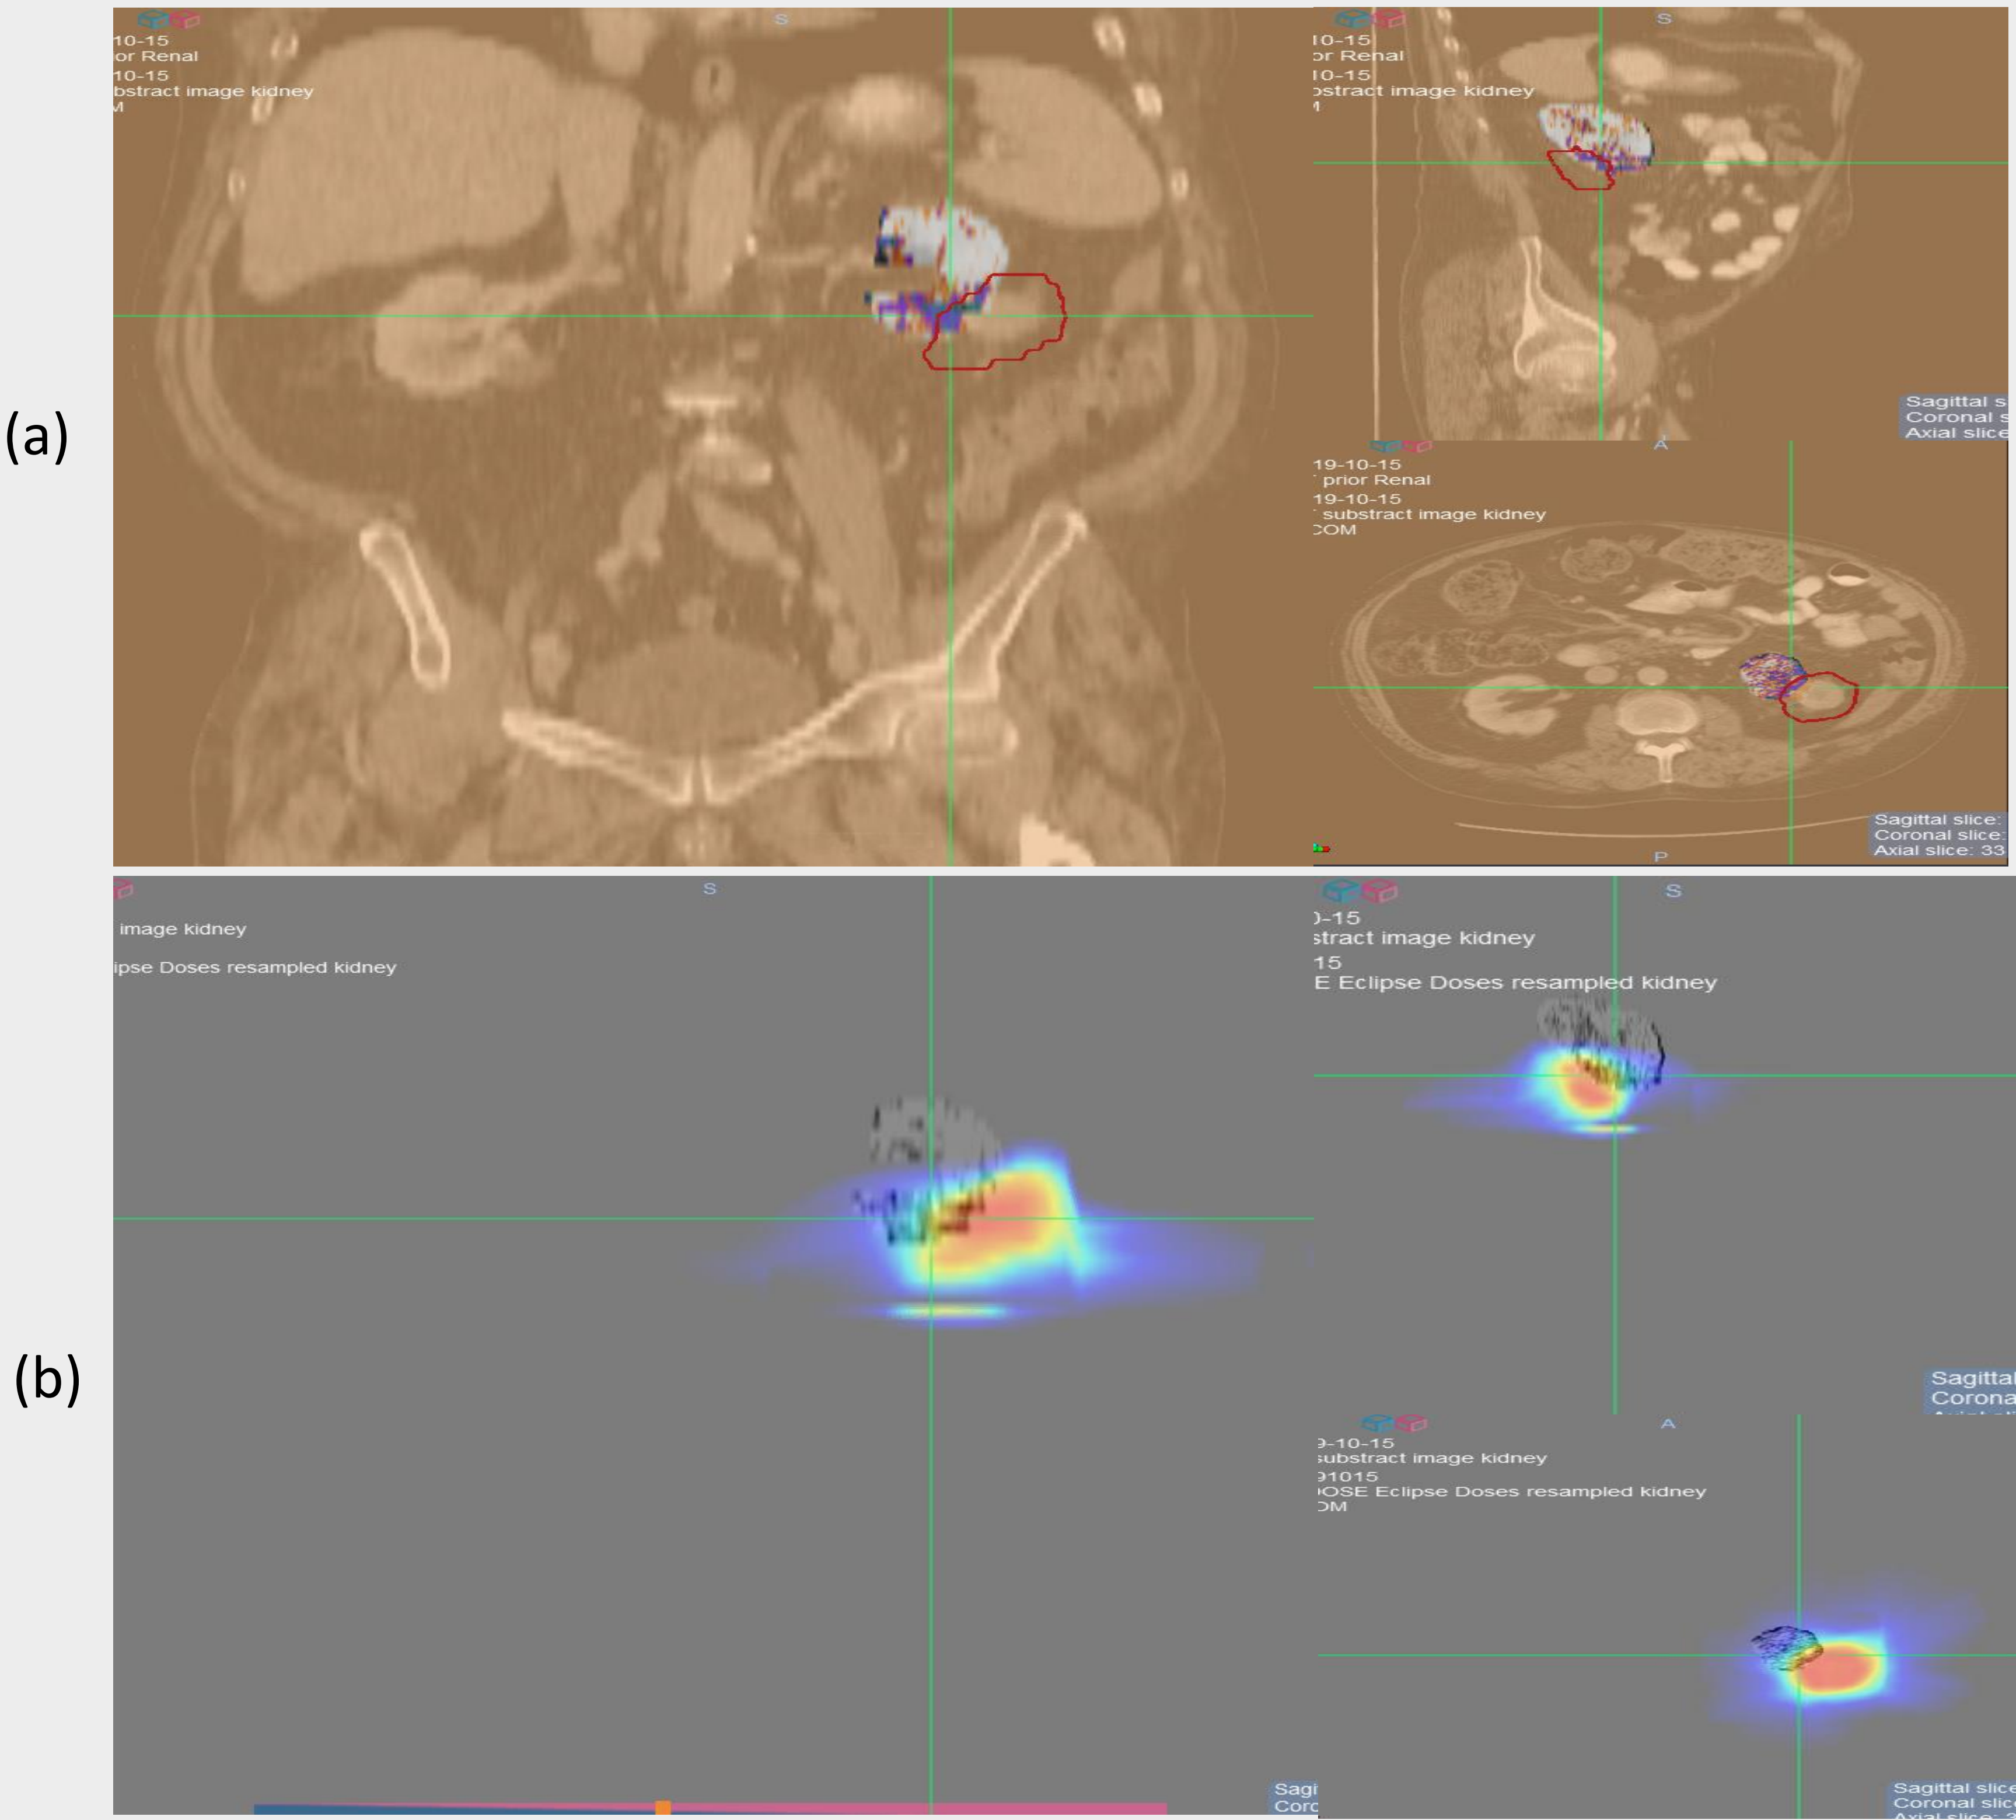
An example of the 3D view of the subtracted image overlaying with prior SBRT CT (a) and Dose (b).
